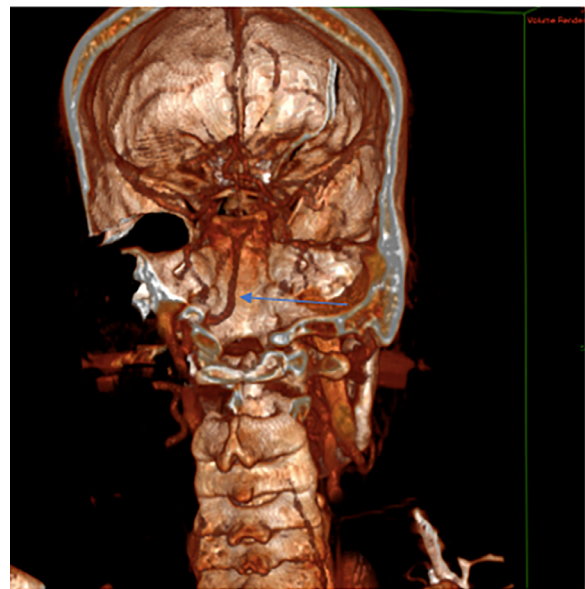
Coronal CT 3D reformat shows the basilar artery is coming through the hypoglossal canal.
